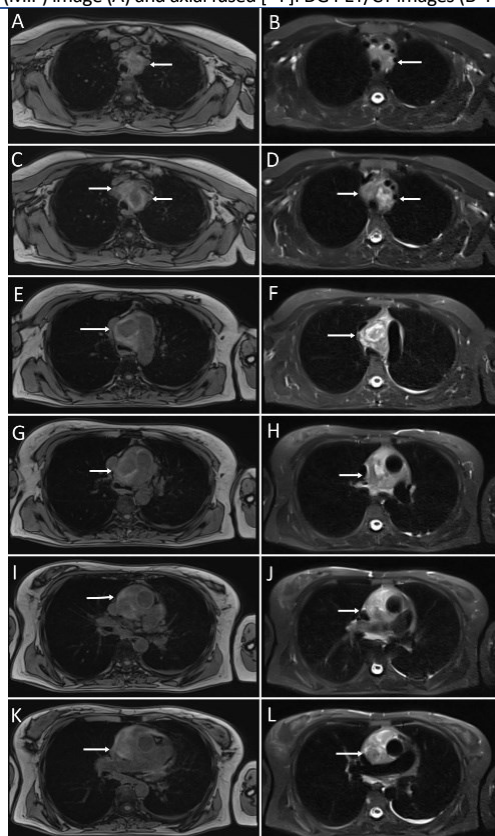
Axial T1-weighted images (A, C, E, G, I, K) and axial T2-weighted images (B, D, F, H, J, L) from the thoracic MRI
